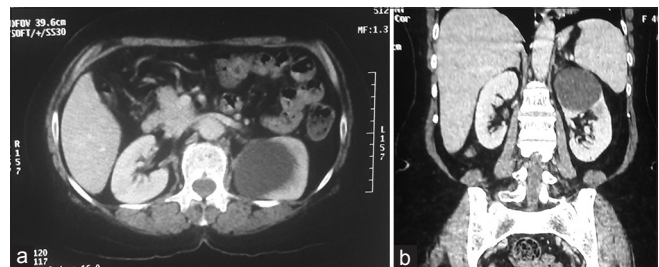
Contrast-enhanced computed tomography kidney, ureter, and bladder equally showing a single large simple cyst (79.3 mm × 63.6 mm × 62.8 mm) at upper pole of the left kidney. (a) Axial plane. (b) Coronal plane
